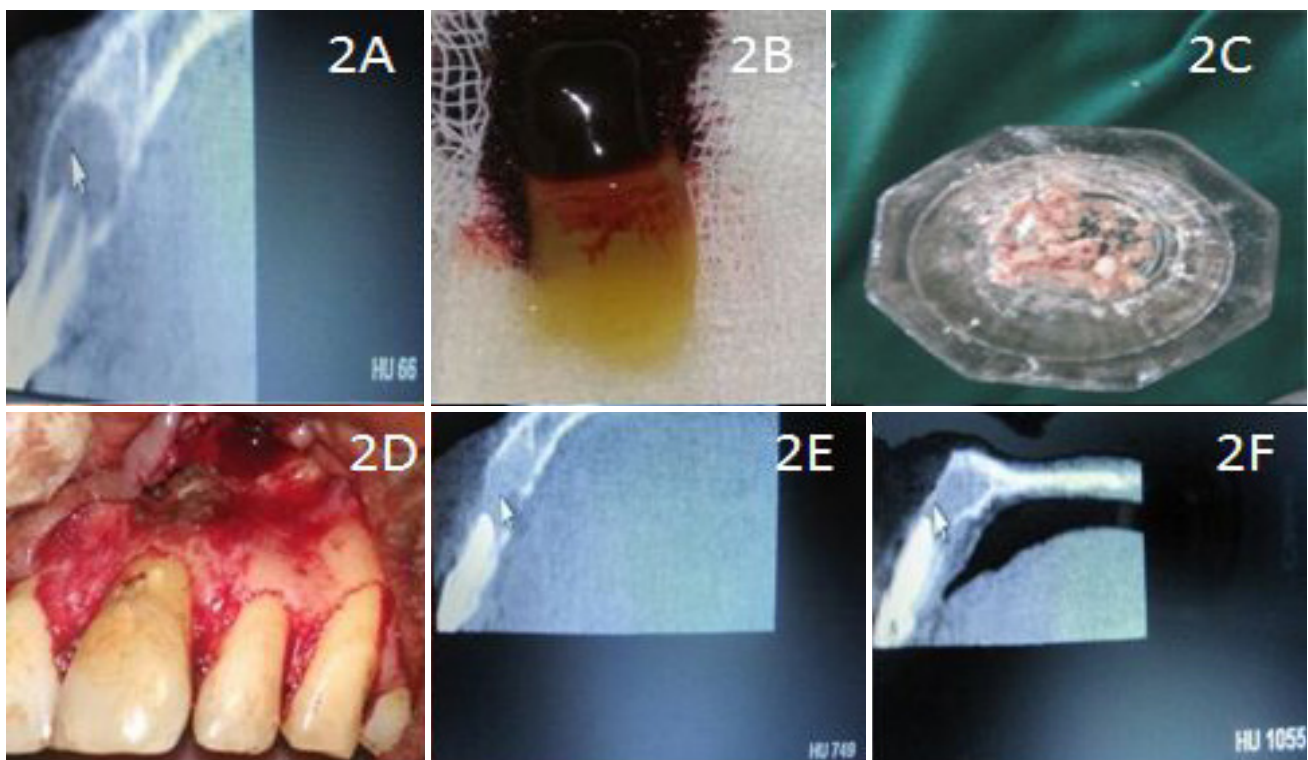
A. Preoperative CBCT image with HU value; B. Preparation of PRF; C. Mixing of PRF with β -TCP; D. Placement of PRF + β -TCP in the defect; E. 6 months post-op CBCT image with HU value; F. 1 year post op CBCT image with HU value.
